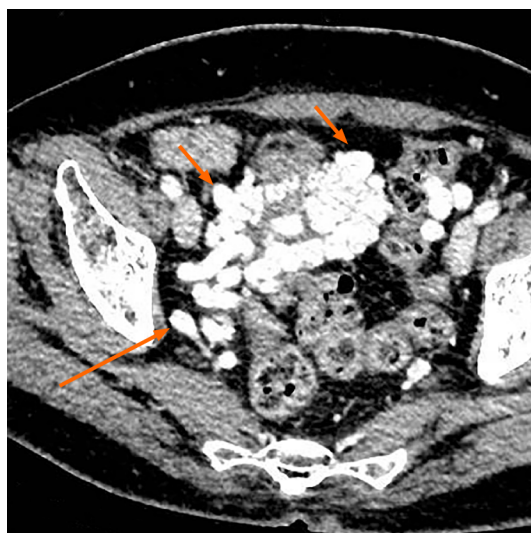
Axial contrast-enhanced computed tomography image demonstrating multiple tortuous and thickened veins on the anterior wall and both sidewalls of the bladder (short arrow). The dilated vesical varices on the right side drained into the internal iliac vein (long arrow).
